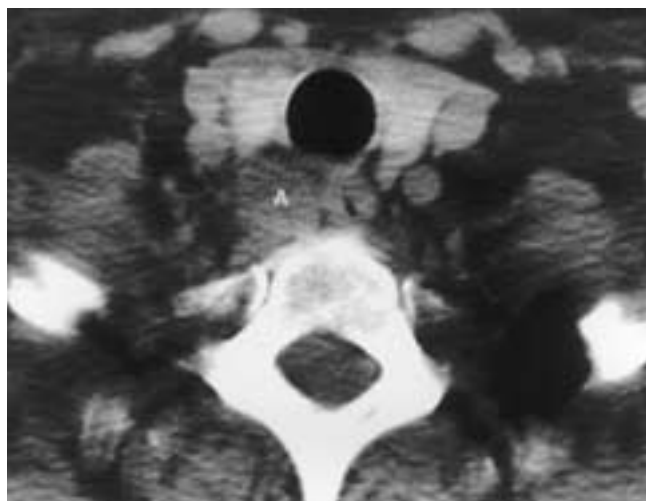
Parathyroid adenoma in the right perithyroidal region. Axial CT image shows the adenoma (A) that was detected in the evaluation of this patient with hypercalcemia.
